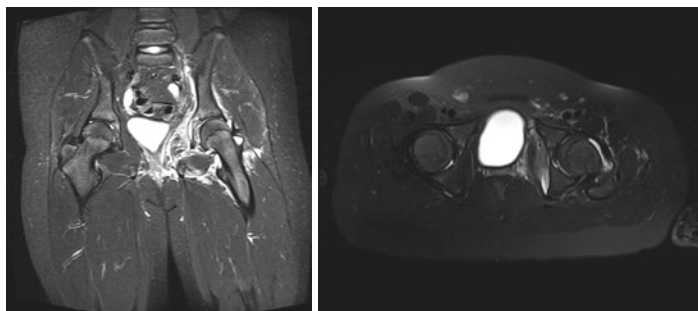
Coronal and axial slices of magnetic resonance imaging (MRI) of patient with complicated septic arthritis of left hip with surrounding myositis as well as increased signal in bony acetabulum concerning for osteomyelitis
